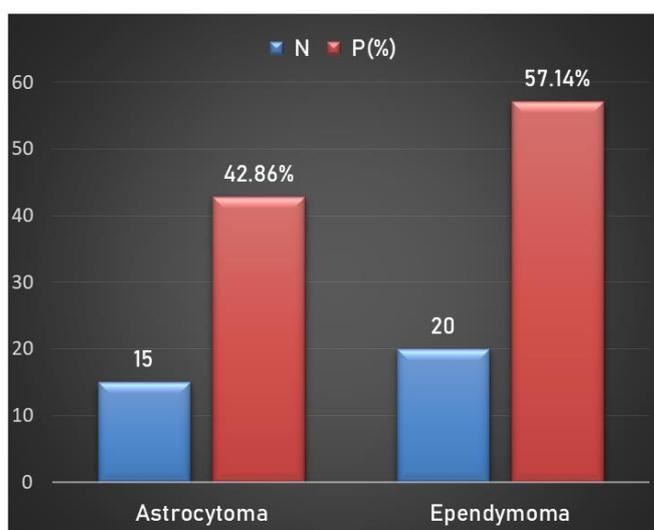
Distribution of intramedullary tumors on the basis of MRI findings
